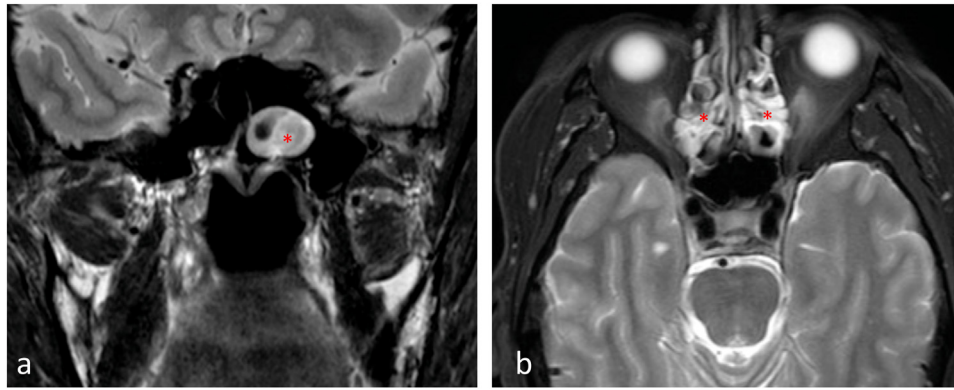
Representative T2-weighted MR images on the coronal (a) and axial (b) planes demonstrating mucosal morphological thickening (asterisks) in the sphenoid sinus (a) and ethmoid sinus (b).
